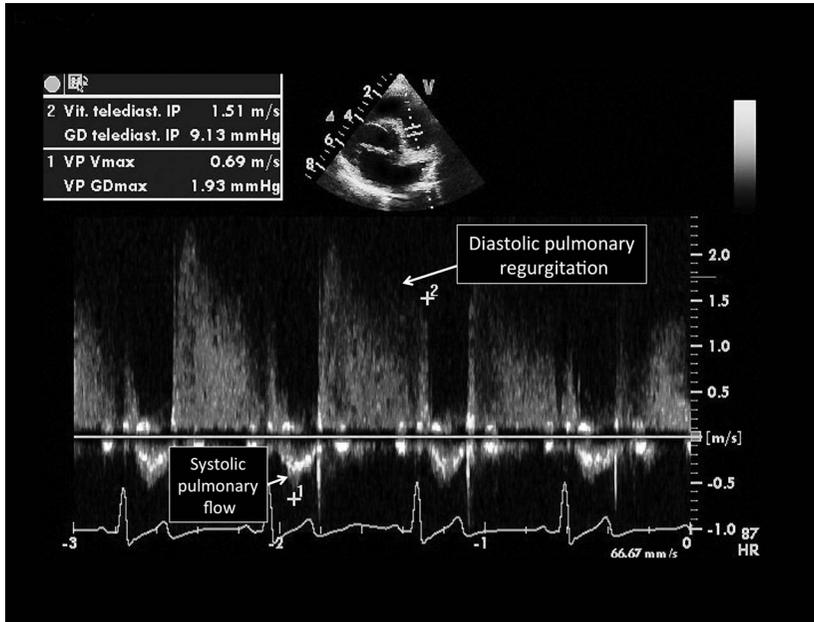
Continuous-wave Doppler trace of pulmonary flow recorded from the right parasternal short axis view at the level of the aortic valve in an “apparently healthy” cheetah (*Acinonyx jubatus*) showing a normal systolic pulmonary flow and a diastolic pulmonary regurgitation. The peak end-diastolic pulmonary regurgitation velocity was measured (1.51 m/sec) to further assess the end-diastolic pulmonary artery-to-right ventricle pressure gradient using the modified Bernoulli equation (9 mm Hg).
